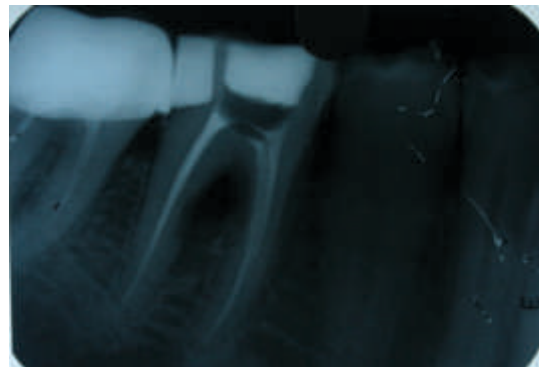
Preoperative radiograph showing well obturated root canal in relation to 36
